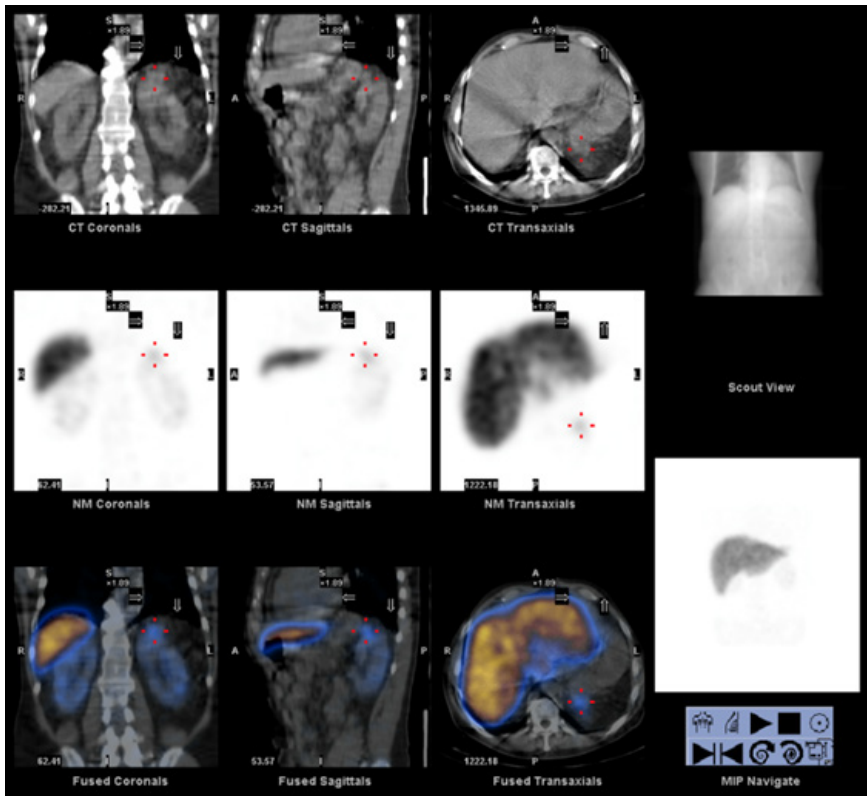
SPECT-CT fusion images of the abdominal region- mild uptake in the post-splenectomy bed at the Scintigraphy suggesting splenosis focus. Liver uptake was globally homogenous with no focal uptake at the site of the lesions depicted on MRI.
